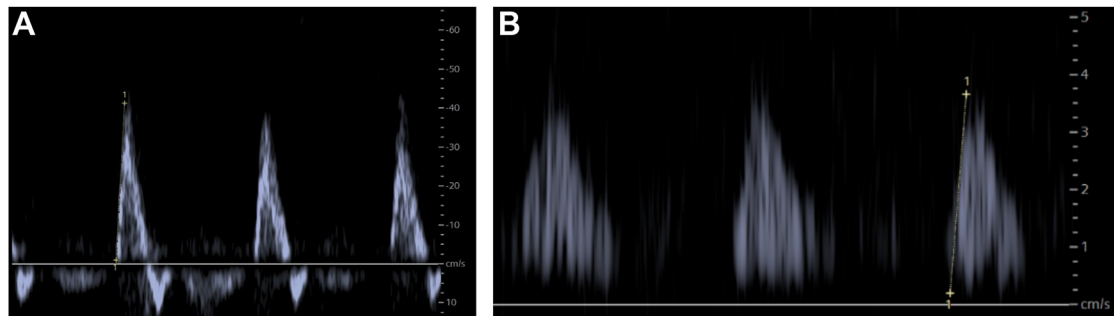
Doppler ultrasonography. (A) Normal triphasic waveform showing an ACC_{max} measurement of 7.6 m/s^2 , calculated at the maximal slope in the systolic phase of an arterial flow (tangent line indicated by 1). (B) Abnormal monophasic waveform at the hallux showing
